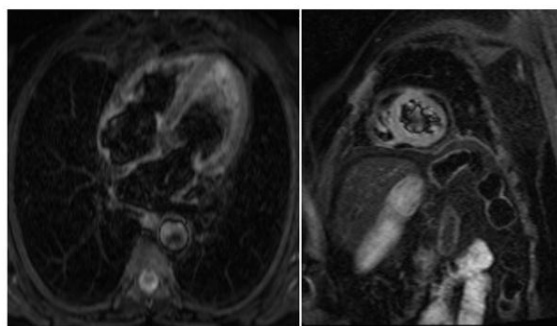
T2-weighted cardiac magnetic resonance image showing myocardial hyperintensity in the apical segments, consistent with myocardial oedema.
